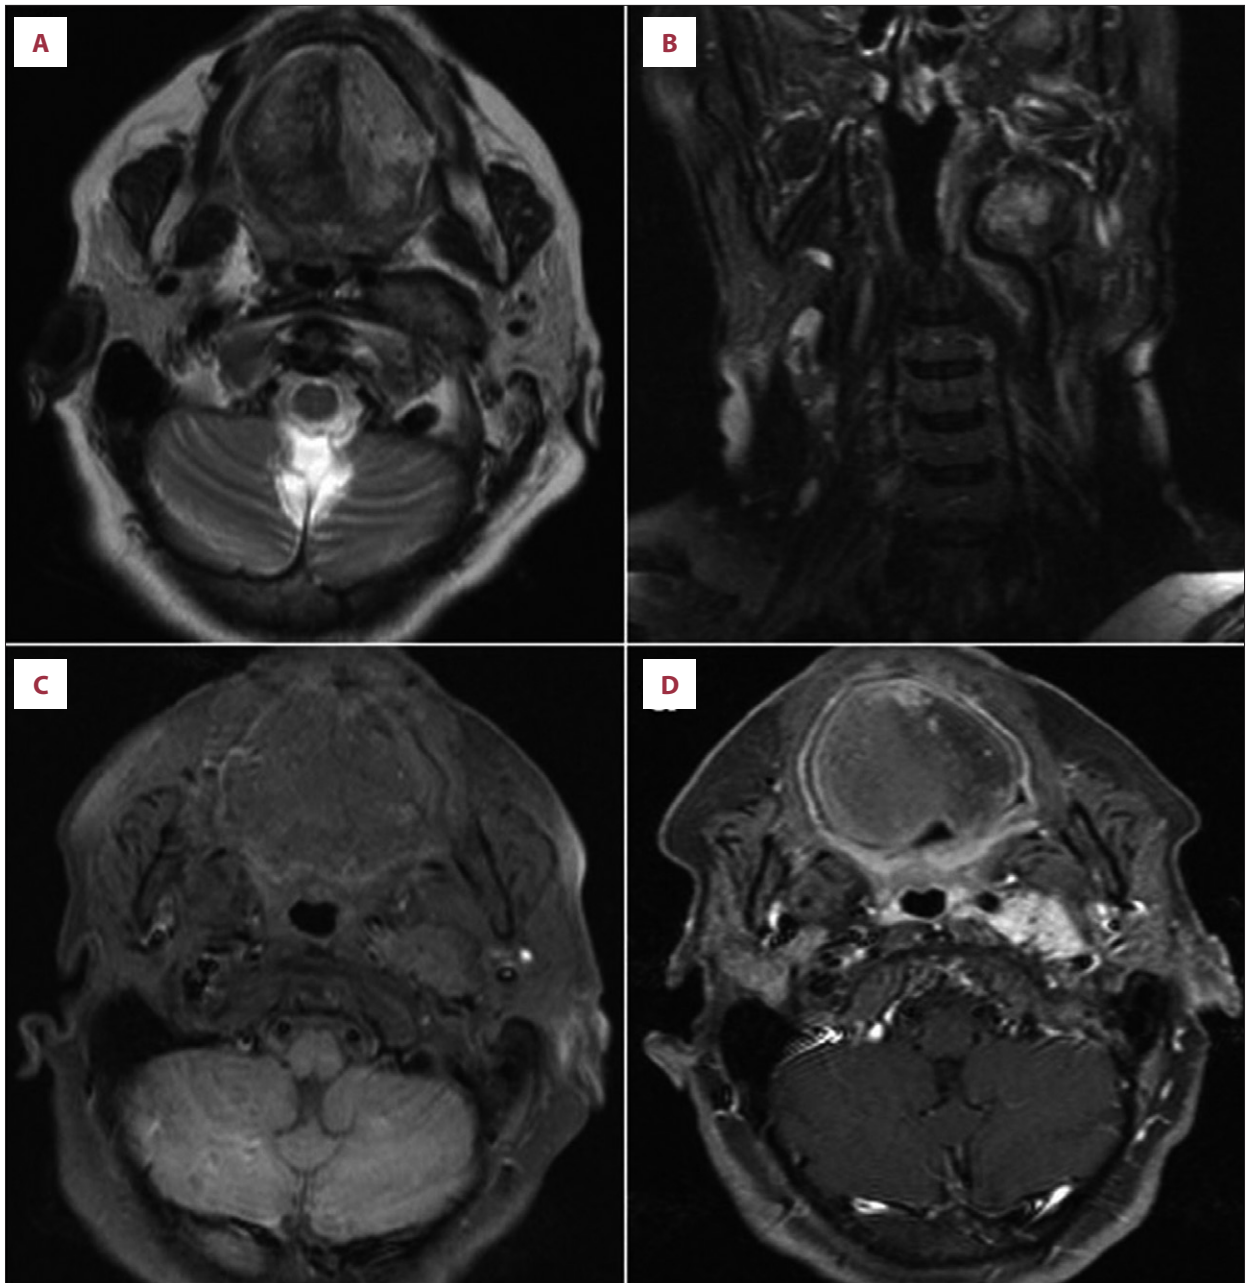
Mildly hyperintense and “salt and pepper” looking lesion, located superior to left carotid bifurcation level between left ICA and ECA, is observed on T2 weighted axial (A) and coronal (B) imaging. Hypointense lesion on T1 weighted axial (C) imaging. Postcontrast T1-weighted axial (D) images demonstrates increased contrast enhancement of lesion. On axial images, atrophy is observed on left half of tongue. Lesion pushed left ICA to anterior and medial.
